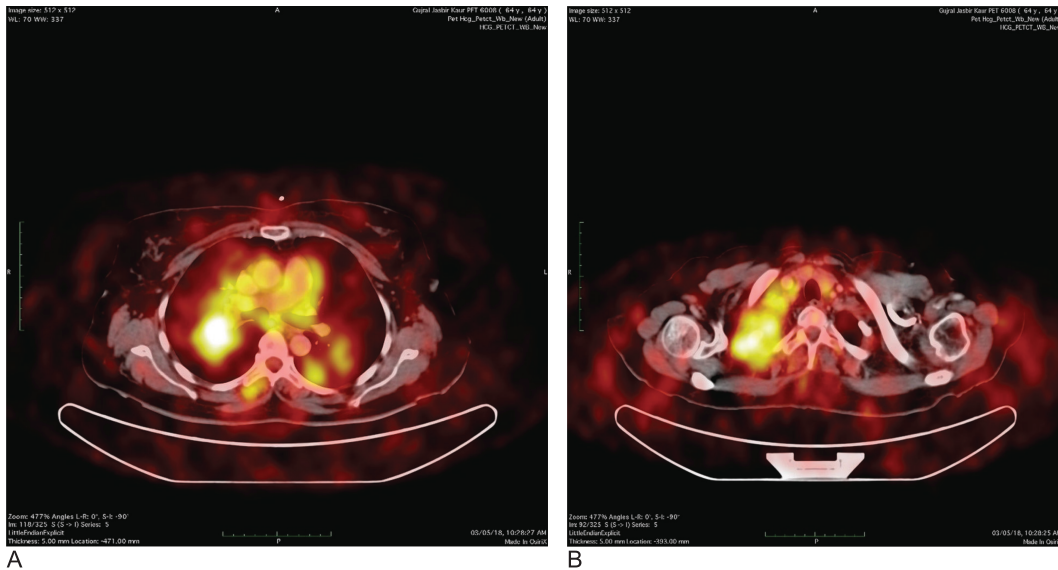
The PET-CT scan—a hypermetabolic heterogeneously enhancing soft-tissue mass in the right upper lobe.
